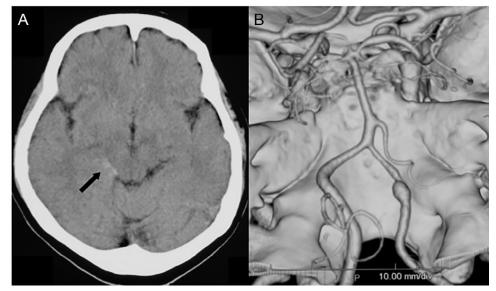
Computed tomography (CT) scanning (A) demonstrates evidence of subarachnoid hemorrhage (arrow). CT angiography (B) shows right vertebral artery dissecting aneurysm (VADA) and the left vertebral artery (VA) are normal.
